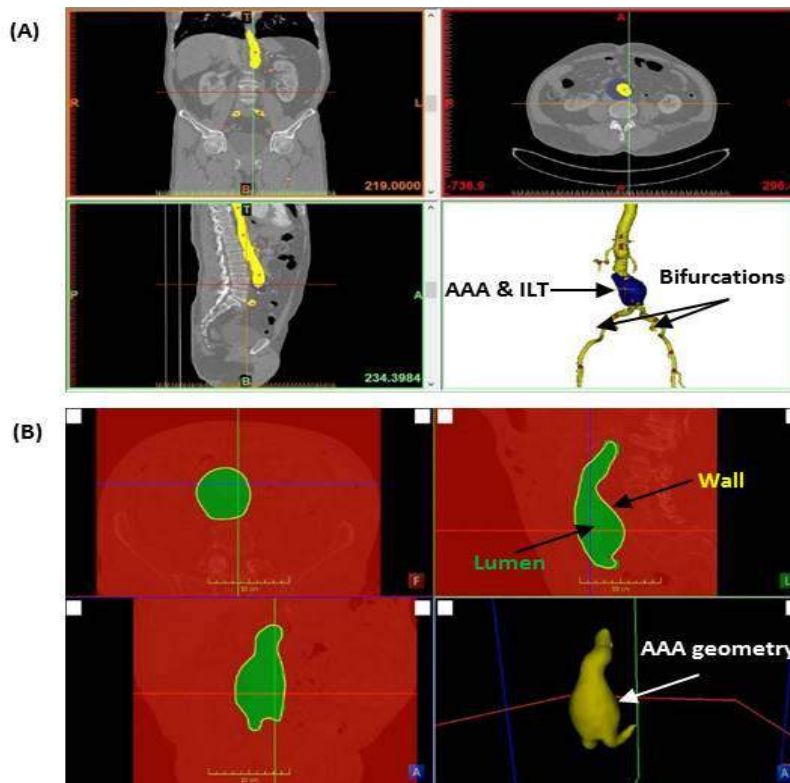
CT images in positions of (coronal, sagittal, and axial) of a patient with AAA: (A) Mimics v.18, (B) ImFusion suite.
